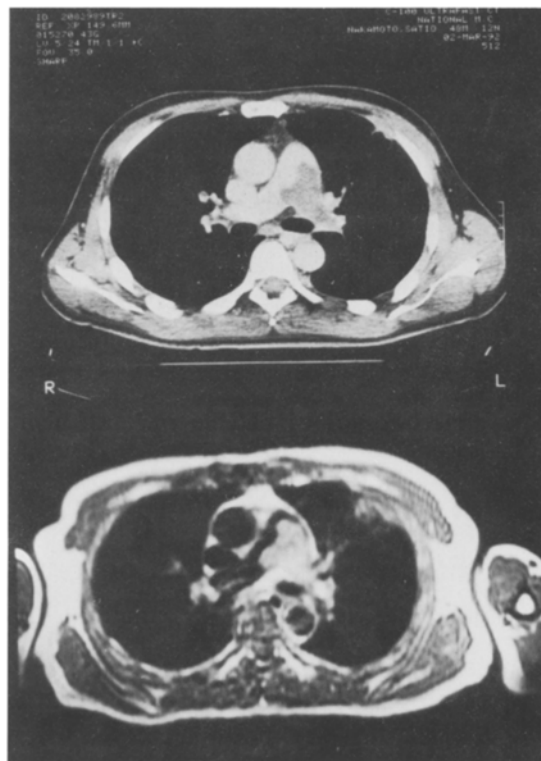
CT (upper panel) and MRI (lower panel) images of pulmonary arteries obtained just prior to open-heart surgery. The tumor thrombus in the left pulmonary artery is clearly demonstrated as a hypointense mass (upper panel) or a hyperintense mass on the T1-weighted image (lower panel)
